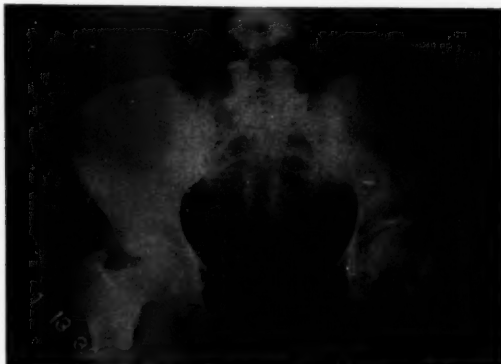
(Case 3). Roentgenogram of the pelvis with an extensive lipoma involving the region of the left iliac fossa and surrounding the upper end of the left femur. The shadow which represents one edge of the lipoma passes through the date line on the roentgenogram.
